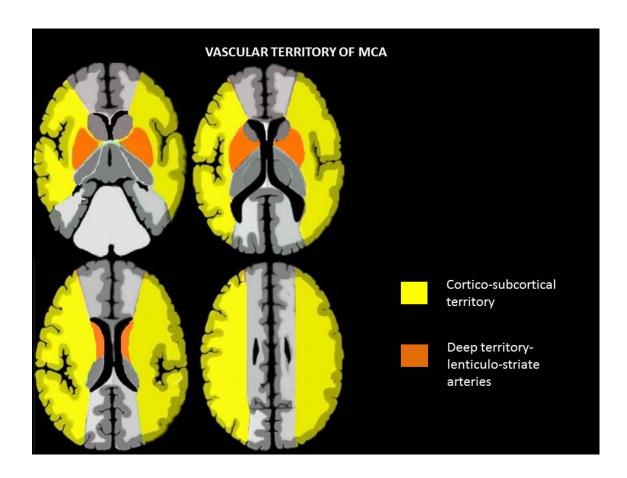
MRI of vascular territory of MCA (Popa, 1970). Yellow and orange coloured areas are MCA territory. Non-highlighted area is anterior and posterior cerebral artery territory.
